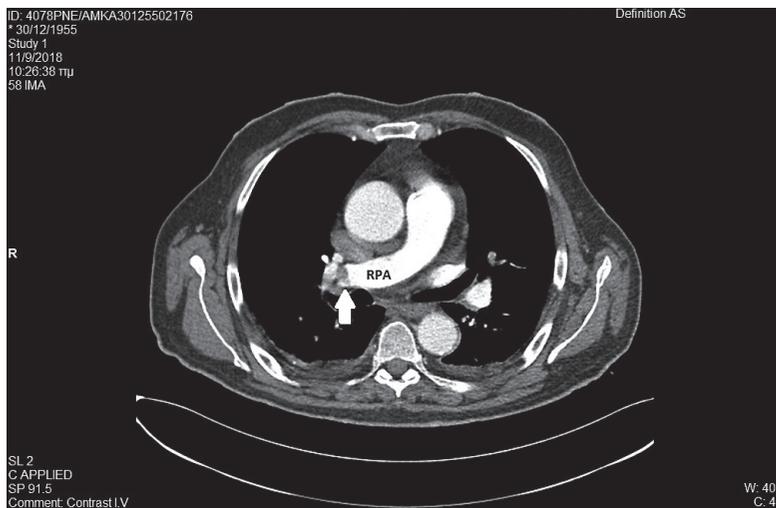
CTPA after fibrinolysis and hemodynamic stabilization revealed a large, residual thrombus (white arrow) in the main branch of the right pulmonary artery (CTPA – computed tomography pulmonary angiogram; RPA – right pulmonary artery).
